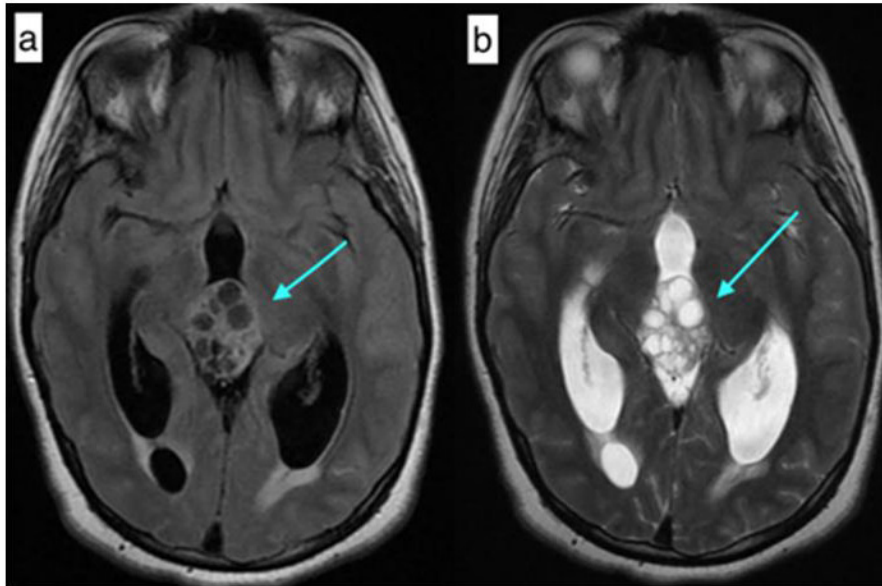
a- MRI T1 sequence with gadolinium injection b- T2 FLAIR sequence
